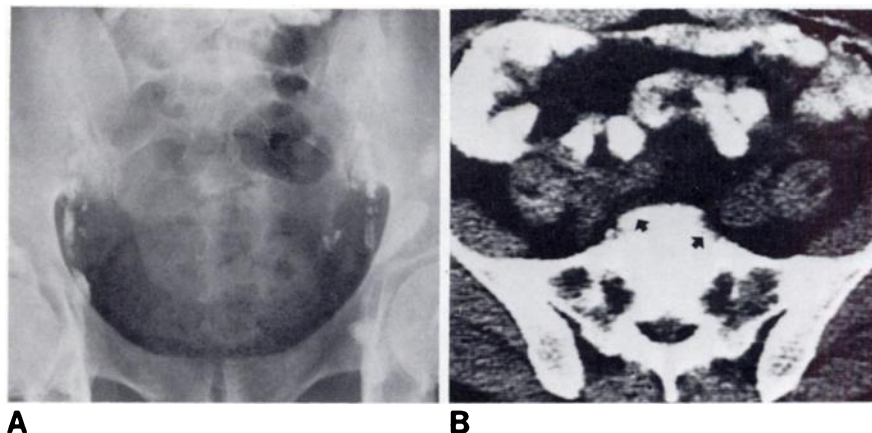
False-negative lymphangiogram. A, Negative. (Note contrast in colon from prior barium study.) B, CT through pelvis. Bilateral soft tissue prominence in hypogastric nodes (arrows). Nodes were positive at surgery.
